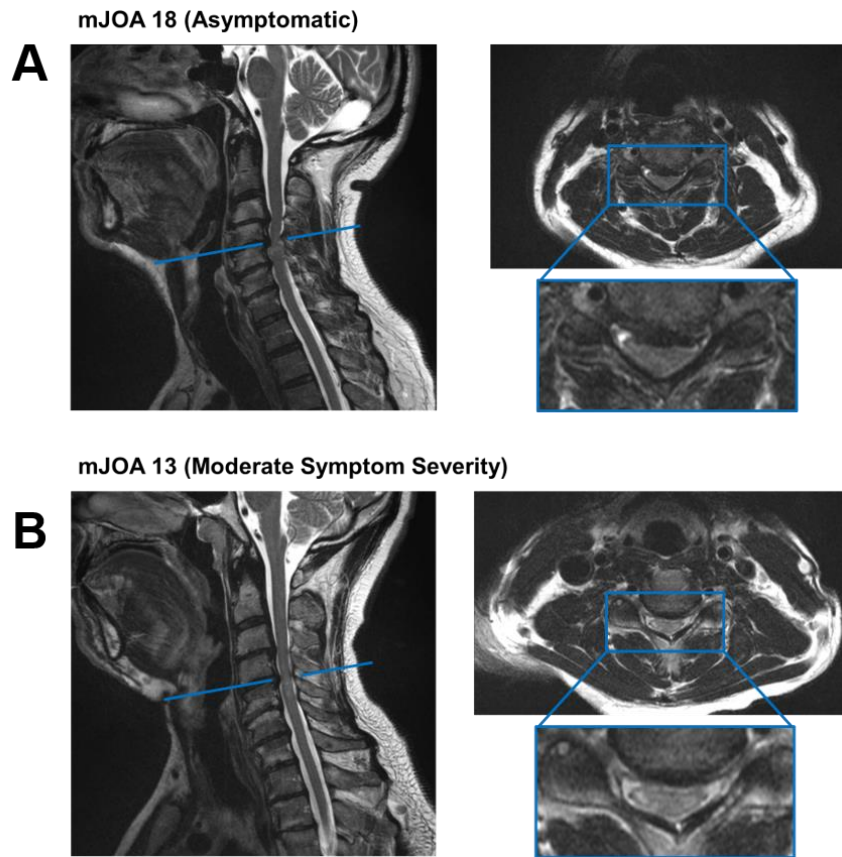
Paradoxical relationship between findings on routine clinical MRI scans and neurological symptoms. T2w sagittal (left) and axial (right) scans are shown. A) patient with high degree of cord compression and some T2w signal hyperintensities in the cord, but no neurological symptoms (mJOA 18). B) patient with moderate degree of cord compression and T2w signal hyperintensities, but moderately severe symptoms (mJOA 13).
